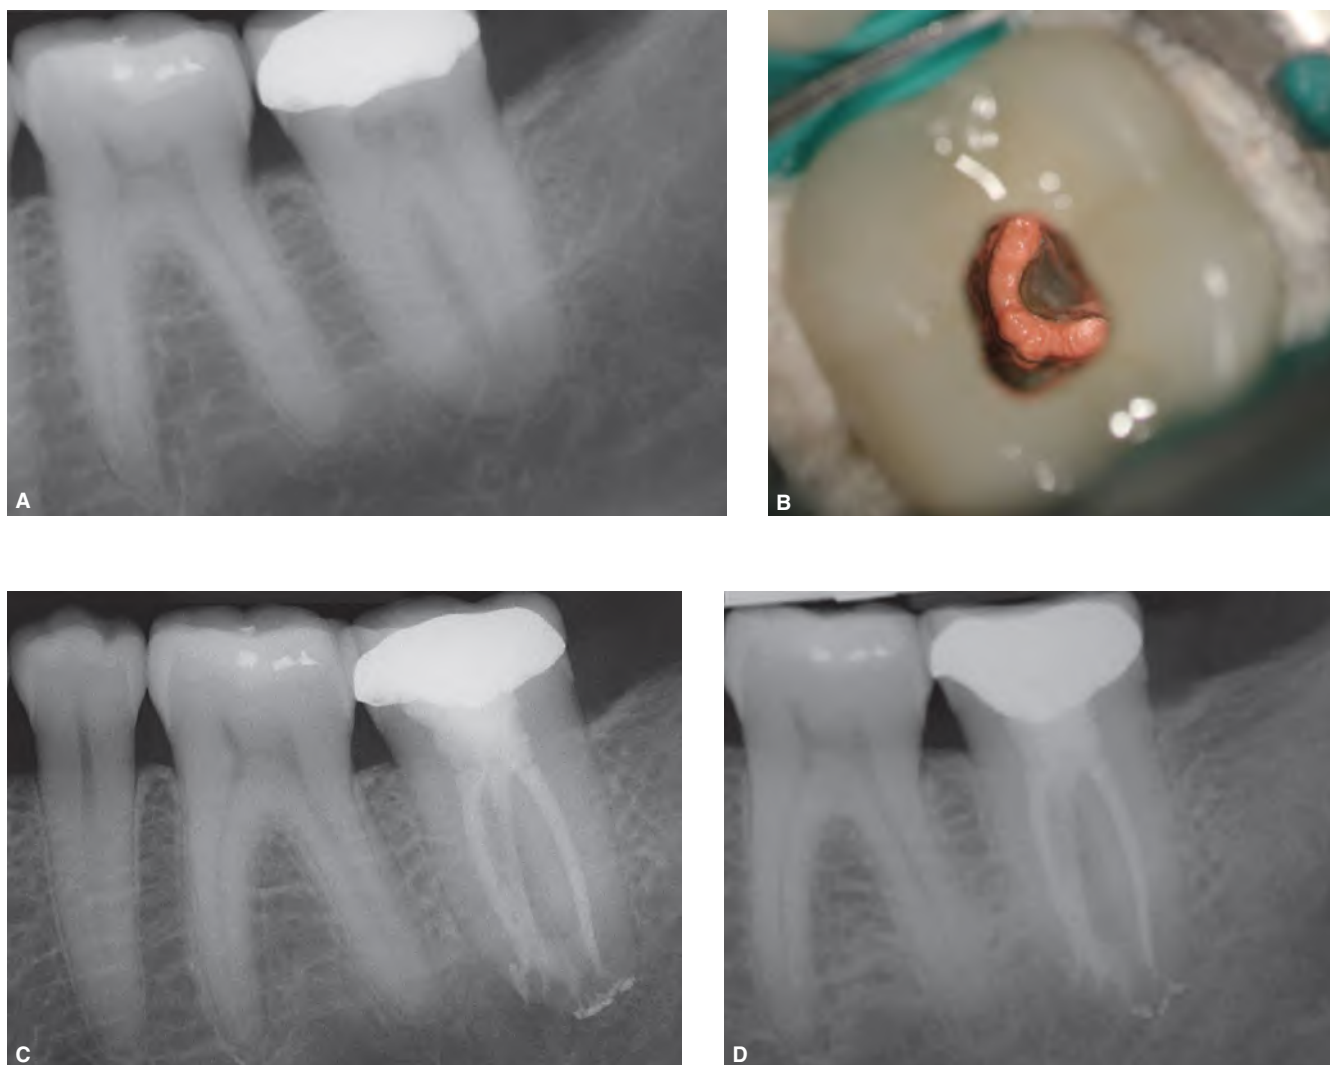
C-shaped canal in a mandibular second molar of a 40-year-old female. Pulp sensibility tests were negative. A. Preoperative radiograph. B. Clinical view of the access cavity after obturation of the root canal system. C. Immediate postoperative radiograph. Note the “shift” of the mesial canal toward the furcation area. This is a typical phenomenon. D. One-year recall radiograph. The patient is asymptomatic and the tooth is functional. (Courtesy of Dr. Rajiv G. Patel, Flower Mound, TX.)
